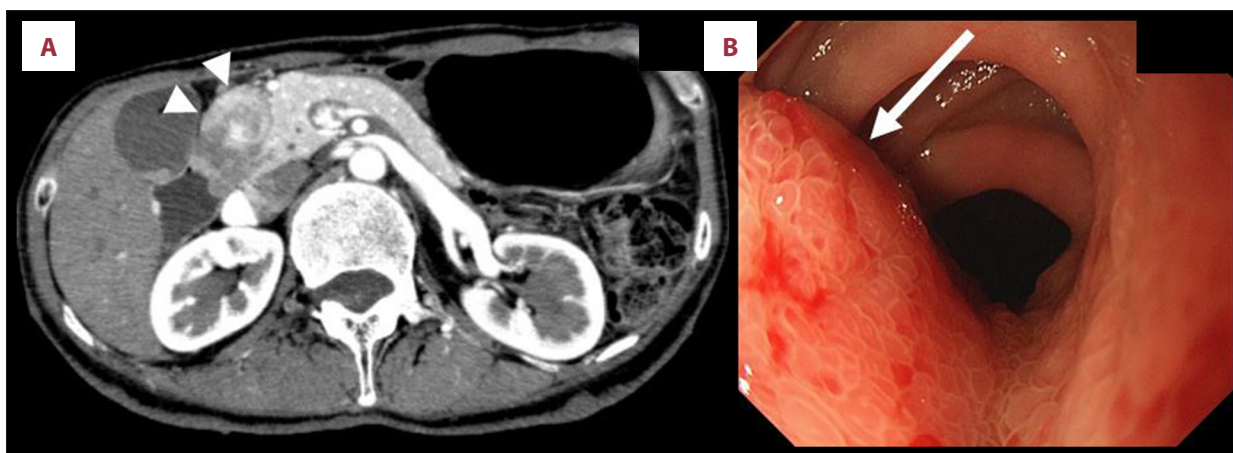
A contrast-enhanced abdominal computed tomography showing that the duodenal tumor was a 4-cm mass-like wall thickening centered on the submucosa (arrowhead) (A). Gastroduodenoscopy revealed a partially stenosed irregular mass in the postbulbous area of the duodenum (arrow) (B).
